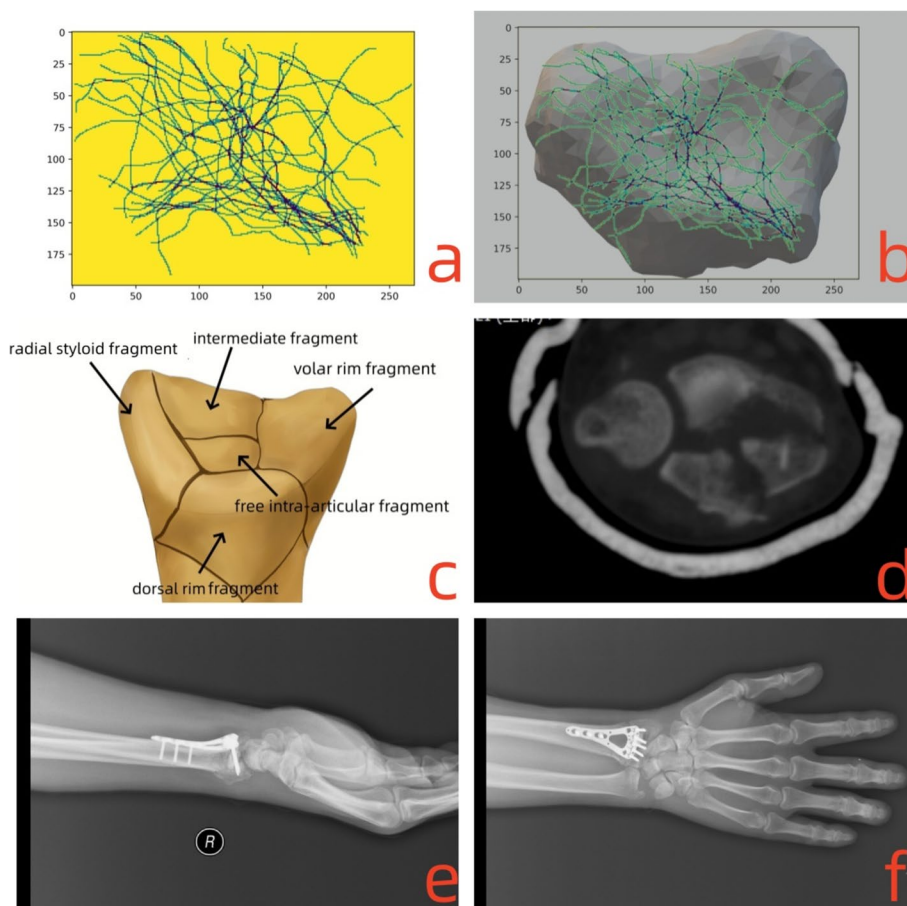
For type 3.1 DRFs, the fracture lines derived from the sigmoid notch, dorsal side, radial side and volar side, and crossed along the interfossal ridge forming like “x” shape. The morphological characteristics and the clinical treatment were shown as follows: a-b) the fracture lines clustered and covered on the intra-articular surface; c) the model for type 3.1 DRFs; d) the CT scan for the fracture lines at the articular surface; e)-f) postoperative posteroanterior and lateral X-ray images
